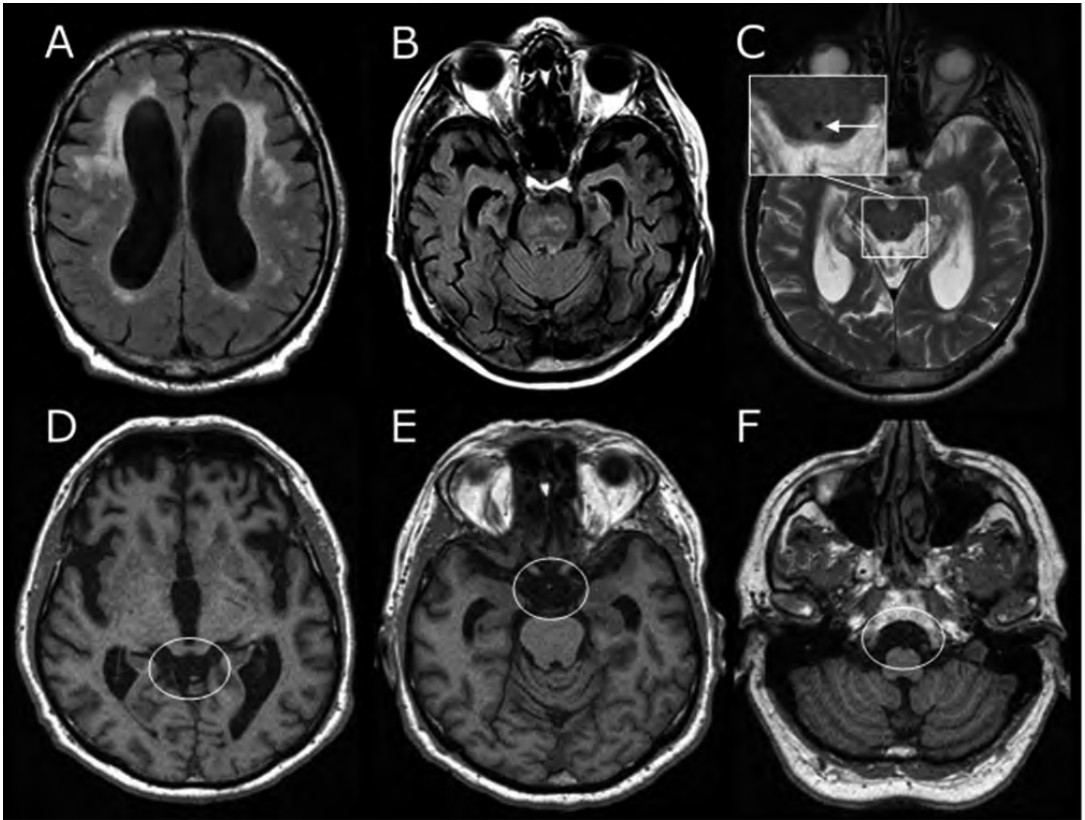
The radiological markers used in iNPH and the differential diagnostics. A. Periventricular and deep white matter hyperintensities, beginning confluence on the Fazekas scale, axial T2 FLAIR 1.5-T MRI. B. Brain stem white matter hyperintensities, beginning confluence, axial T2 TIRM (turbo inversion recovery magnitude) 1.5-T MRI. C. Aqueductal flow void (arrow), axial T2 1.5-T MRI. D. Mildly enlarged quadrigenital basal cistern marked by circle, axial T1 1.5-T MRI. E. Mildly enlarged supracellar basal cistern marked by circle, axial T1 1.5-T MRI. F. Mildly enlarged infrapontine cistern marked by circle, axial T1 1.5-T MRI.
